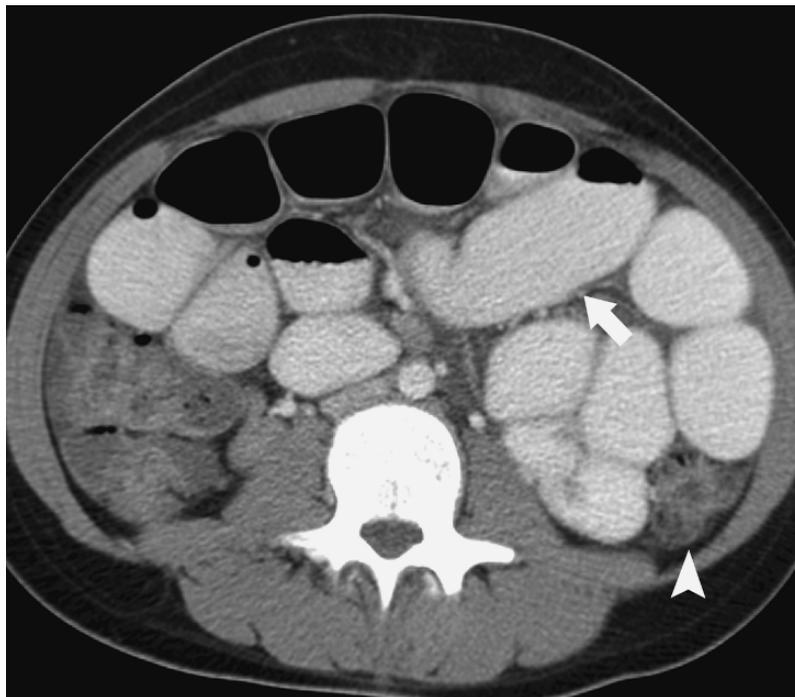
SBO. Axial image from abdominal CT demonstrating dilated small bowel (arrow) and collapsed colon (arrowhead). Not shown is high-grade distal ileal obstruction caused by severe inflammatory bowel disease.
